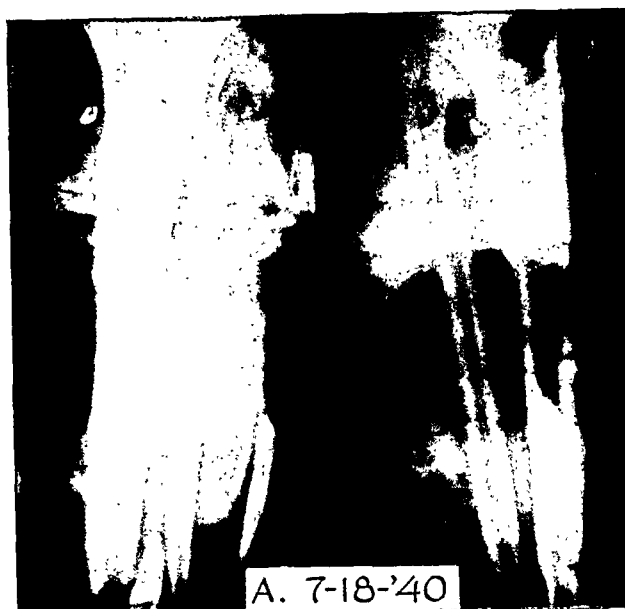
Case vi. *A*, roentgenogram of leg in plaster exhibits a "ring" sequestrum. *B*, roentgenogram about one month after sequestrectomy. *C*, roentgenogram on July 5, 1941, shows that the fracture is united and that there is filling in of bone at the site of the sequestrectomy. All of the roentgenograms reveal an old osteomyelitis of the upper end of the tibia which followed a gunshot wound several years before the present admission.
